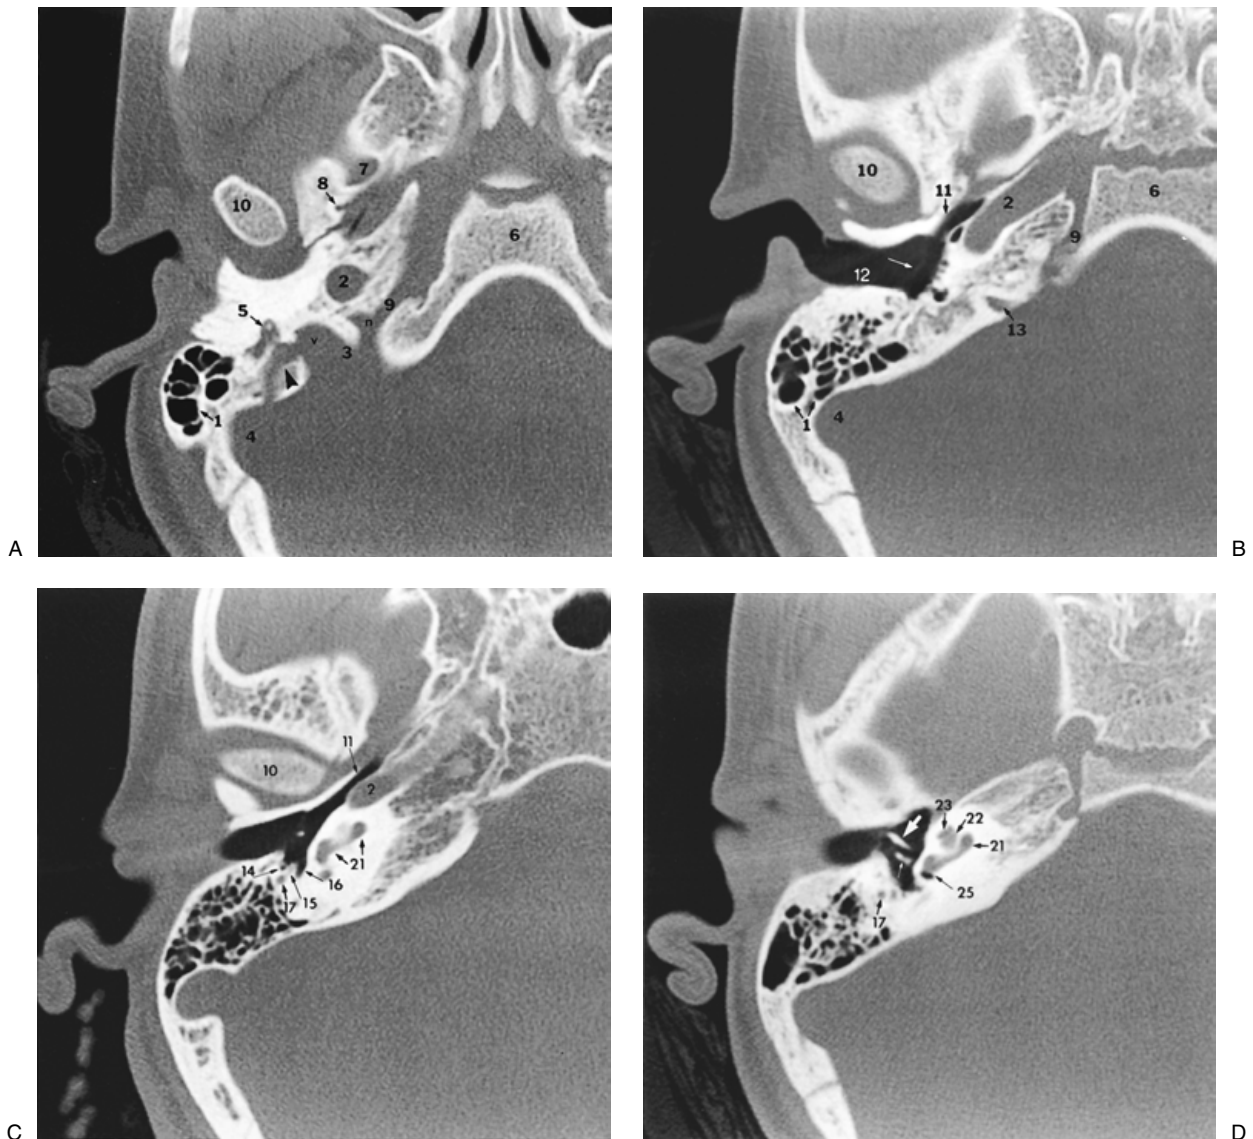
Normal anatomy, axial computed tomography. Images progress from inferior (A) to superior (G). Images are from different patients. (A) Skull base. Skull base foramina are well delineated. An unusual emissary vein drains into the jugular bulb (arrowhead). (B) Eustachian tube. The bony eustachian tube lies lateral and anterior to the horizontal segment of the petrous carotid canal (white arrow, tympanic membrane). (C) Posterior tympanic recesses. (D) Ossicles and inner ear: mesotympanum (thick white arrow, manubrium of malleus; thin white arrow, lucent space of incudostapedial joint). Medial to the joint space (toward the cochlea) is the head of the stapes; lateral to the joint is the lenticular process of incus. (E) Ossicles and inner ear: mesotympanum (double white arrow, neck of malleus; single white arrow, long process of incus; black arrows point to margins of the oval window). The stapes crura are seen as thin white linear structures projecting into the oval window; the arrow pointing to the modiolus lies in the fundus of the internal auditory canal. (F) Ossicles and inner ear: epitympanum. Malleus and incus have an ice cream cone appearance (double white arrow, malleus
